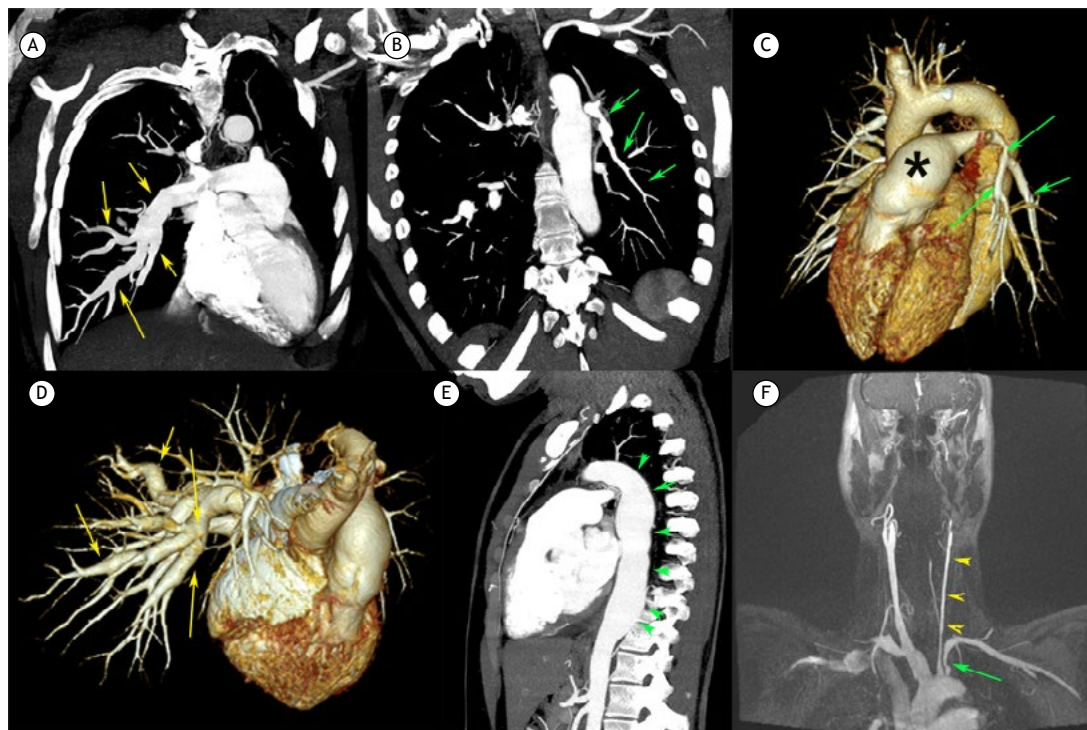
Pulmonary CT angiography images with maximum intensity projection (MIP; A and B), three-dimensional volume-rendered (C and D), and sagittal MIP (E) reconstruction showing dilation of the pulmonary artery trunk (asterisk in C) and the right pulmonary artery and its lower lobe branches (yellow arrows in A and D), substantial stenosis of the left pulmonary artery tree (green arrows in B and C), and diffuse and irregular aneurysm of the descending thoracic aorta (green arrowheads in E). Coronal MIP reconstruction of a post-contrast T1-weighted fat-saturated carotid magnetic resonance angiography sequence (F) showing diffuse narrowing of the left carotid artery (yellow arrowheads). Note also stenosis in the emergence of the left subclavian artery (green arrow).
